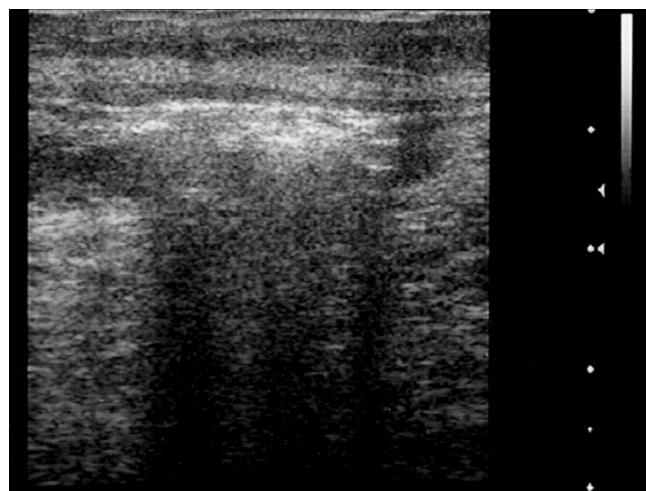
Gas sign - Ultrasonographic
